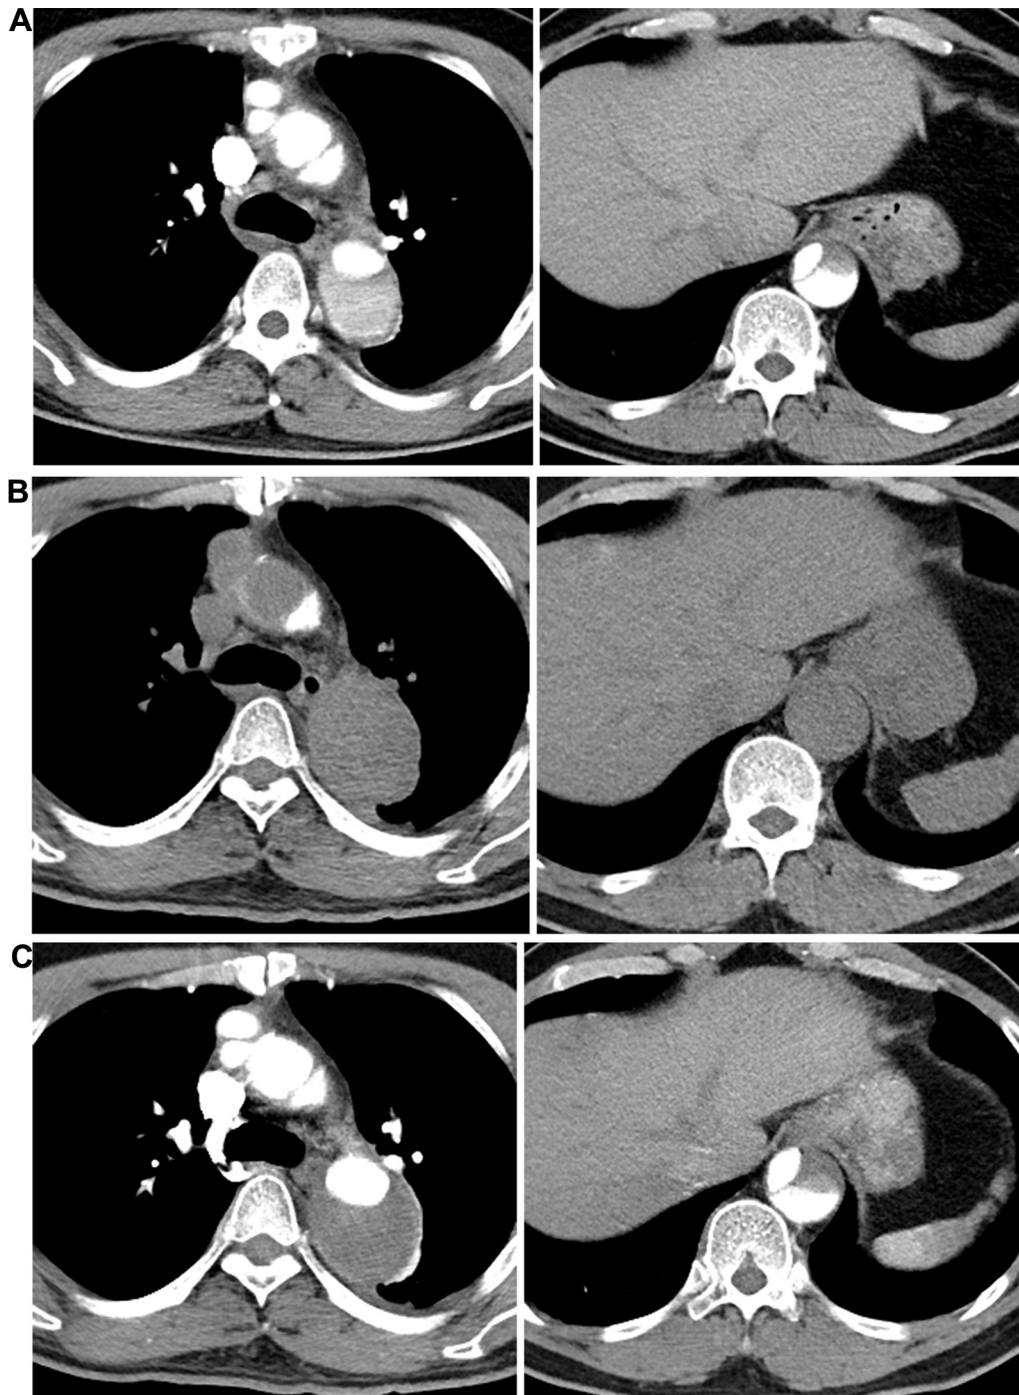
Contrast- and non-contrast-enhanced computed tomography (CT; 6 months ago [A], on admission [B], [C]) showed expansion of false lumen in aortic dissection.
